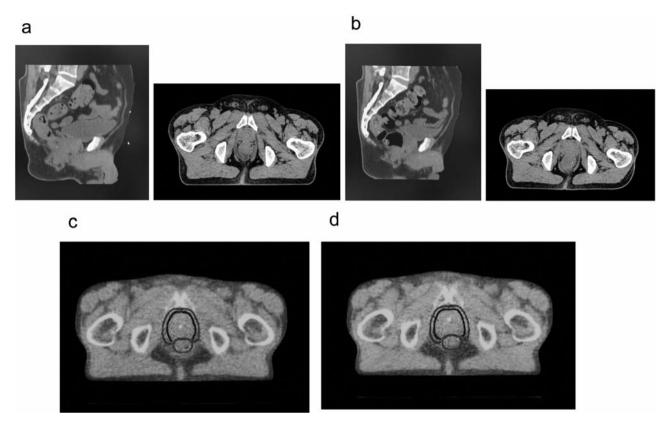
Prostate movement caused by anal contraction: a) Image without contraction, b) image with contraction, c) Megavolt computed tomography (MVCT) before treatment, d) MVCT after treatment revealed contraction. Contraction made the prostate move in anterior and superior directions.
